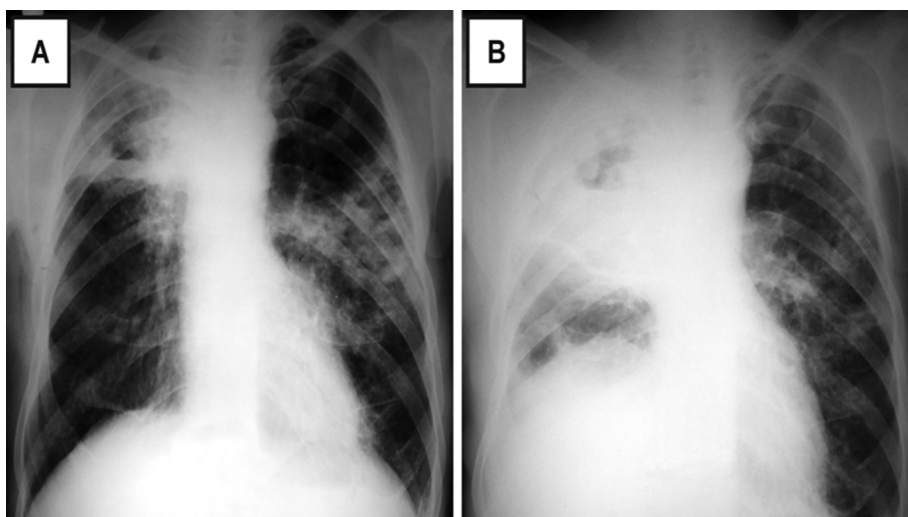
A chest X-ray of 87 year -old male with squamous cell lung carcinoma. During fourth chemotherapy an infiltration was detected in left hemithorax. Sputum smear was positive for AFB. (A) Chest X ray during diagnosis of Pulmonary TB and (B) following for TB treatment.
